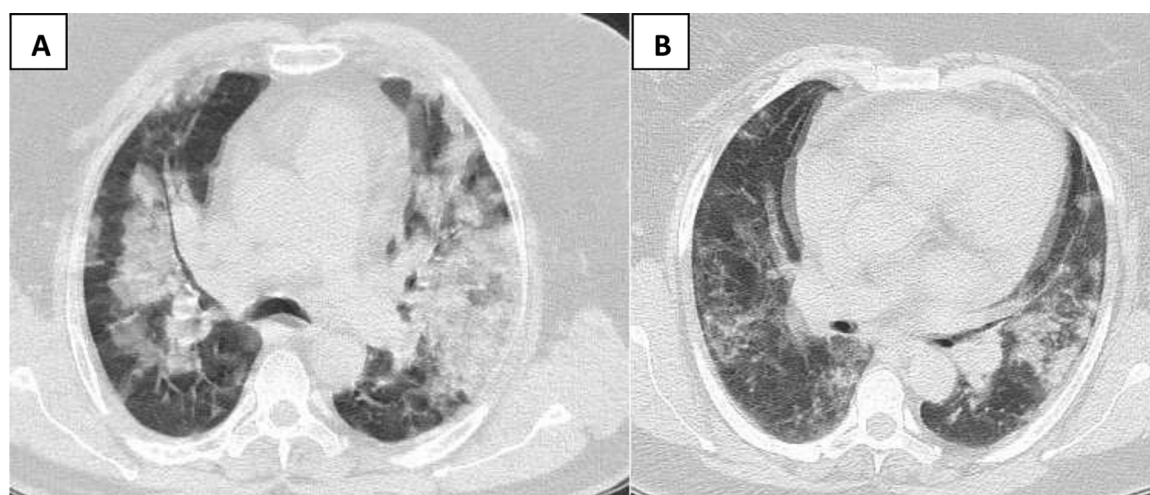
Example of two cases COVID-19 positive treated in Cusco, Peru (3300msnm). Case A) 53 years old male-patient, morbid obese, required ICU care, CT with diffuse consolidation. B) 58-year-old female patient, morbid obese, hospitalized without requiring ICU care, CT with increased extent and density of bilateral lung opacities, with ground glass.
